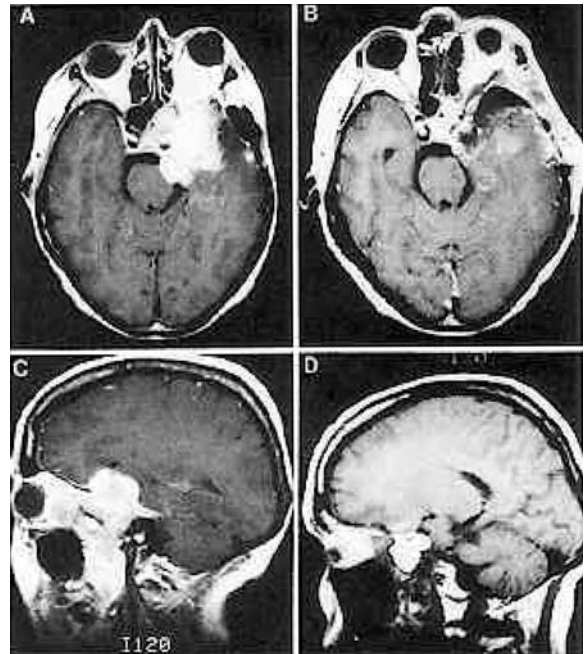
Pre- and postoperative gadolinium-enhanced magnetic resonance images, axial (A and B) and sagittal (C and D) projections (TR 800 msec, TE 20 msec). The extension of this cavernous sinus meningioma into the orbit, the sphenoid and ethmoid sinuses, and the infratemporal fossa through an enlarged foramen ovale is clearly depicted on the preoperative studies (A and C). The postoperative studies (B and D) show complete tumor removal and the presence of autologous fat used to pack the sphenoid sinus.
